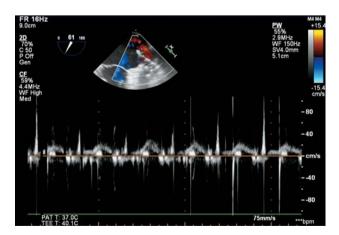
Intraoperative transoesophageal echocardiographic before exclusion of the left atrial appendage, blood flow velocity in the left atrial appendage.
